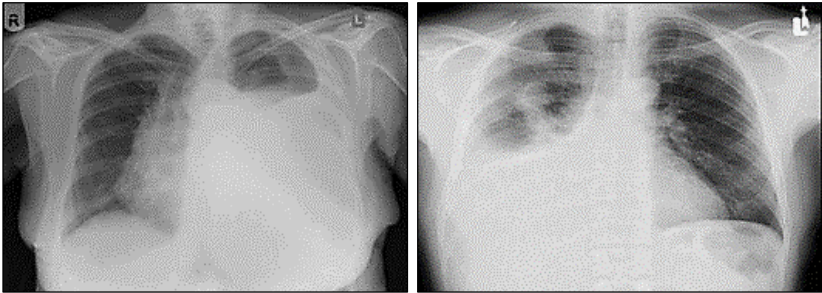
Radiograph of Pleural effusion
